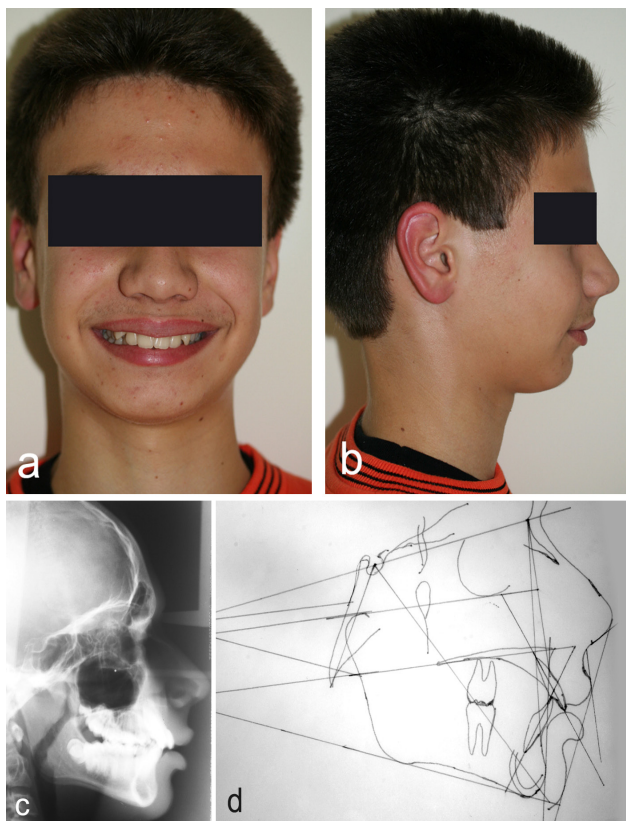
Patient's facial appearance before therapy a) en face, b) profile, c) lateral head radiograph before therapy, d) cephalometric tracing before therapy.
